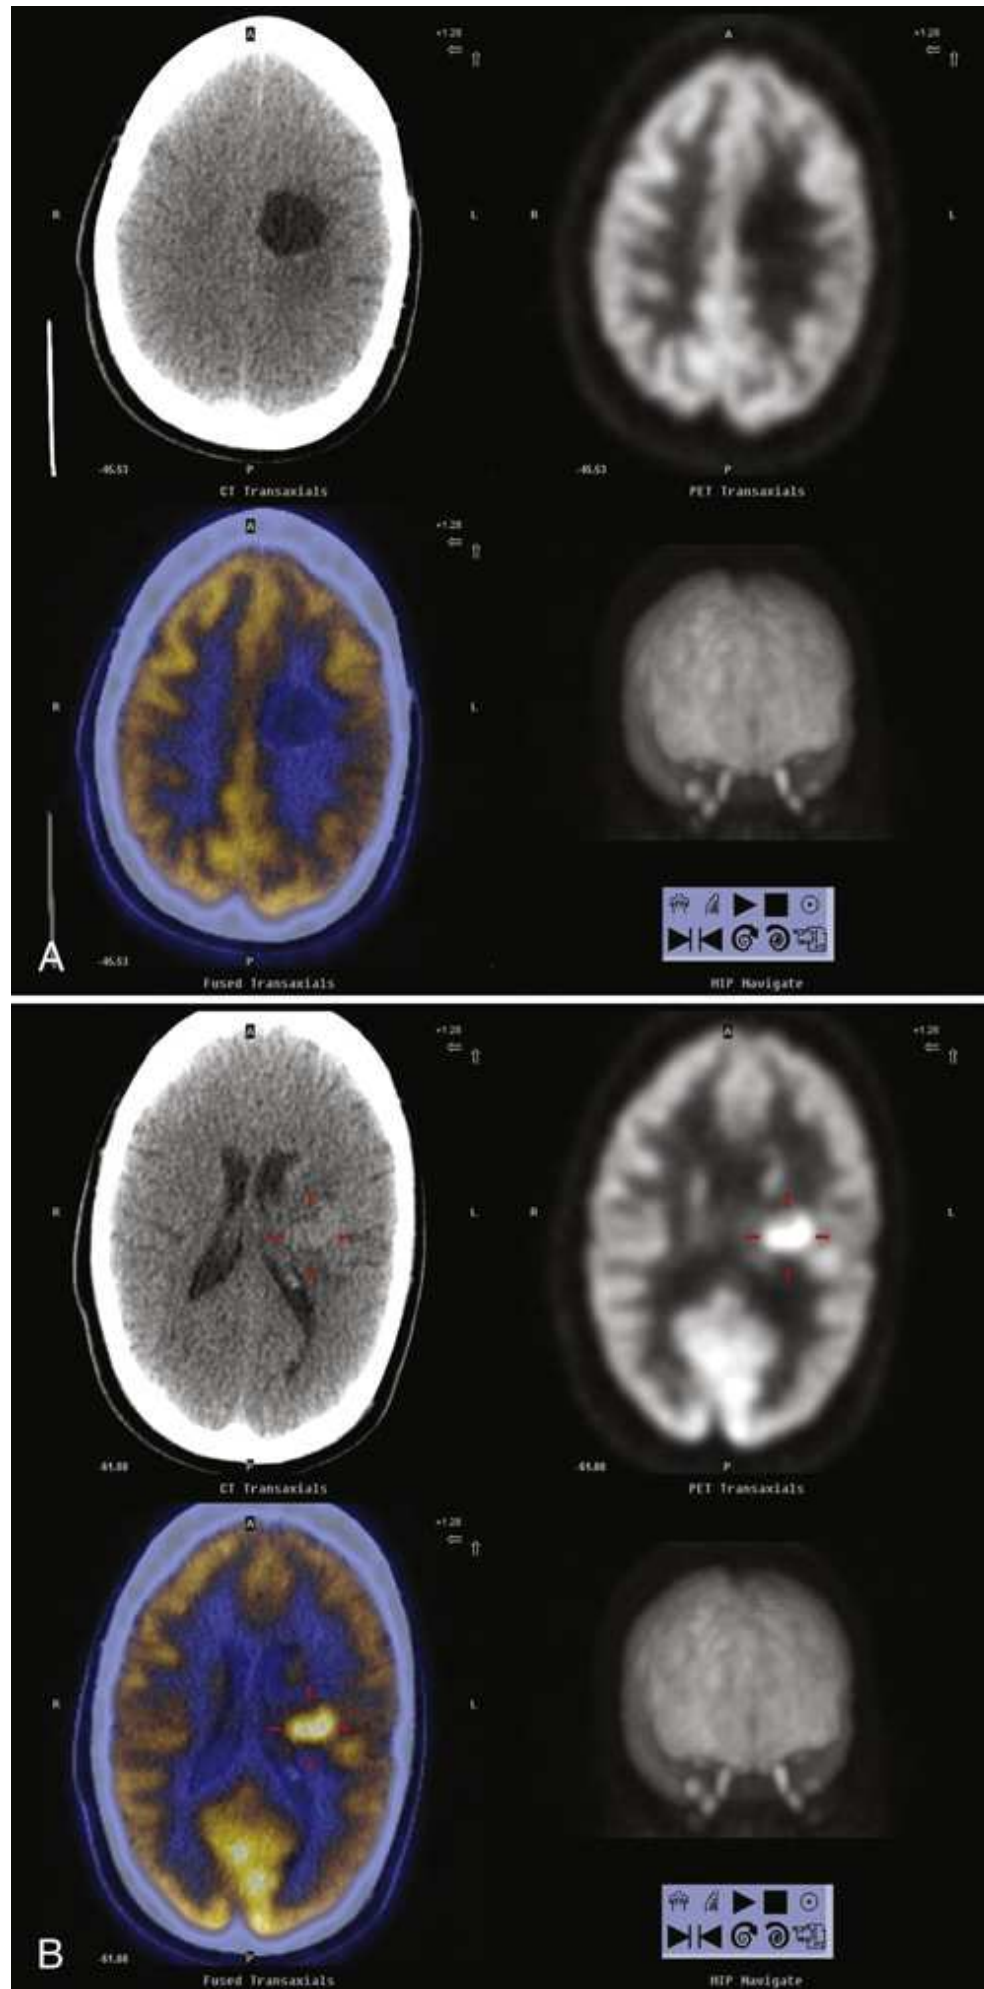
(A) PET FDG brain imaging with CT fusion shows left subcortical resection site consistent with prior tumor resection. (B) At inferior and lateral margins of resection site, in the adjacent white matter, a hypermetabolic mass is identified. This case represents recurrent high-grade malignancy
